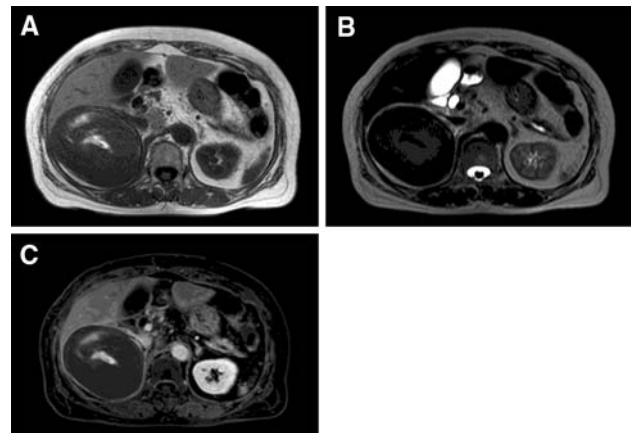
MRI of the abdomen. a T1-weighted image shows hypointense right adrenal tumor with some irregular areas of high signal intensity. b On T2-weighted image, the signal intensity of the right adrenal tumor is heterogeneously low. c Gadolinium-enhanced T1-weighted fat saturation image demonstrates no significant enhancement except for faint enhancement at the rim of the tumor
